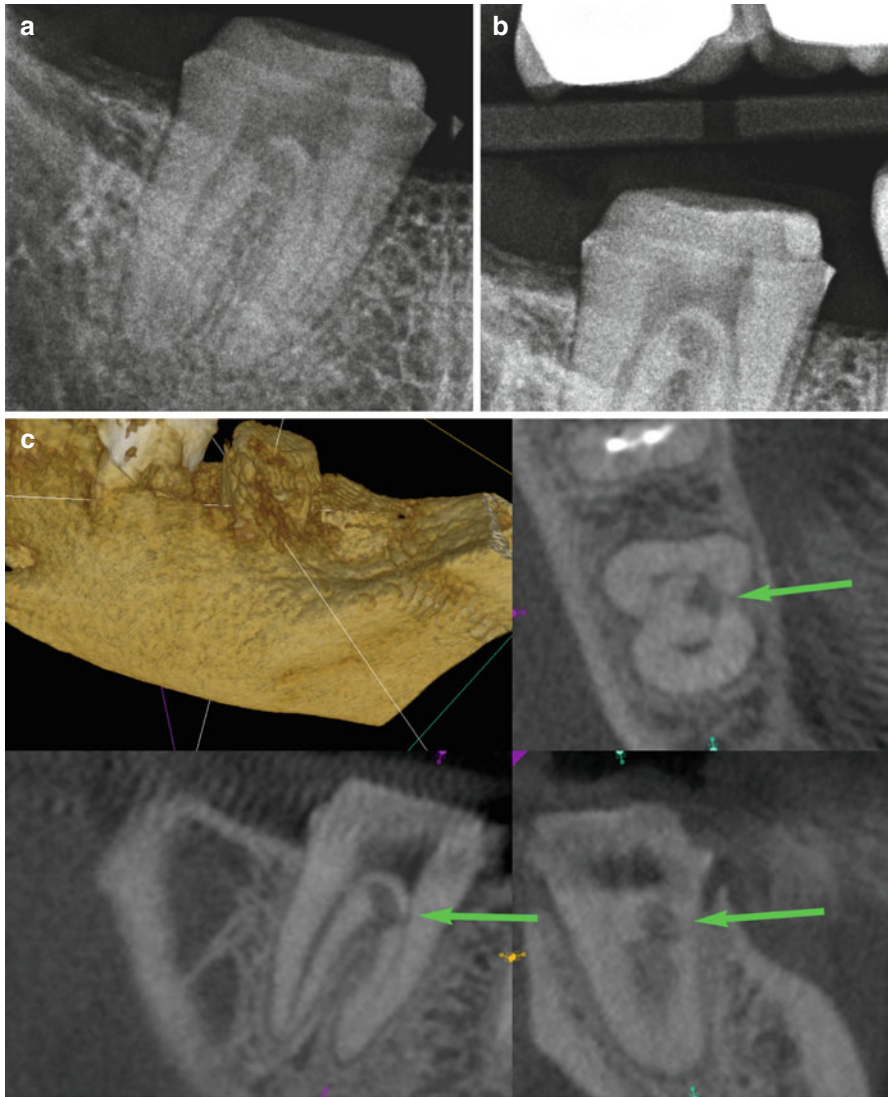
(a) Periradicular radiograph of a mandibular second molar tooth. (b) Bitewing radiograph of the same mandibular second molar tooth. (c) CBCT of the same mandibular second molar tooth demonstrating the position of root resorption in the furcation of the tooth as indicated by the *green arrows*
